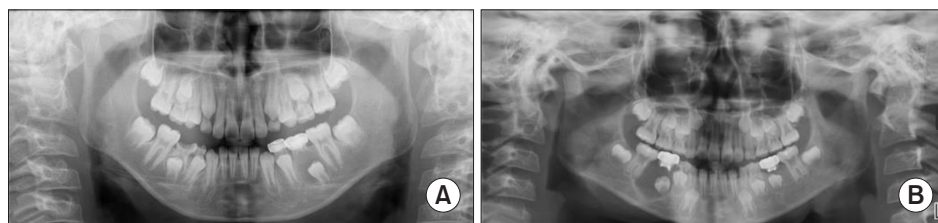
The panoramic radiographs. A. Dentigerous cyst. B. Radicular cyst. Changmo Sohn et al: Cystic lesion between a deciduous tooth and the succeeding permanent tooth: a retrospective analysis of 87 cases. *J Korean Assoc Oral Maxillofac Surg* 2022
